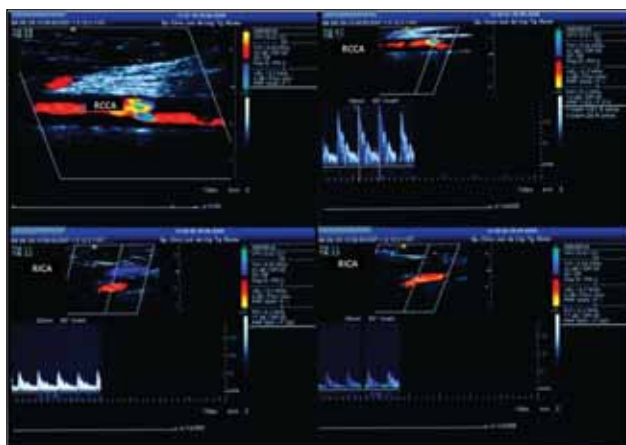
Carotid duplex ultrasonography. Partially recanalized right common and internal carotid artery.
